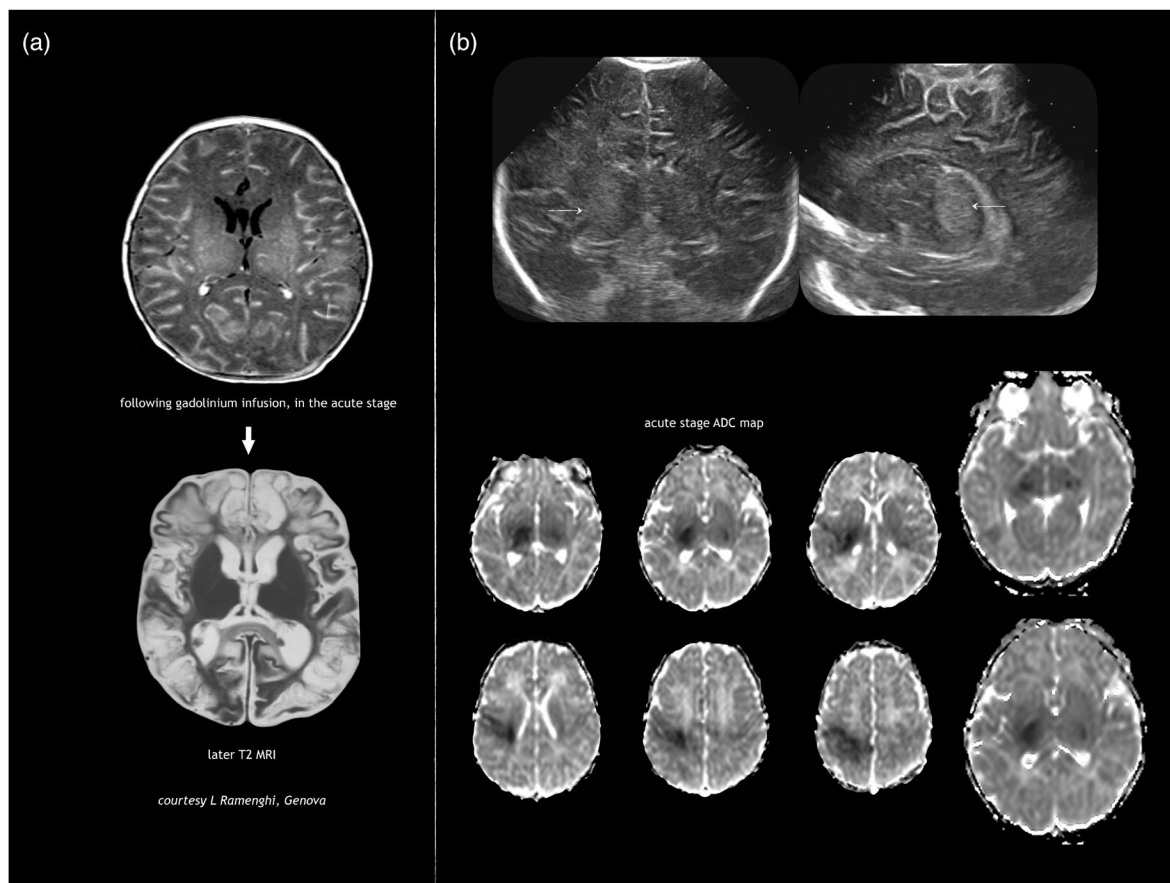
Herpes simplex virus encephalitis. (a) Term-born infant with the acute changes and total brain destruction on MRI, caused by HSV (courtesy L Ramenghi, Genova). (b) A term infant, seizures and fever day 28: thalamo-cortical injury pattern of Herpes simplex virus infection; cranial ultrasound shows hyperechoic change in right thalamus, this is confirmed on ADC map MRI. Abbreviation: ADC, apparent diffusion coefficient; MRI, magnetic resonance imaging.
